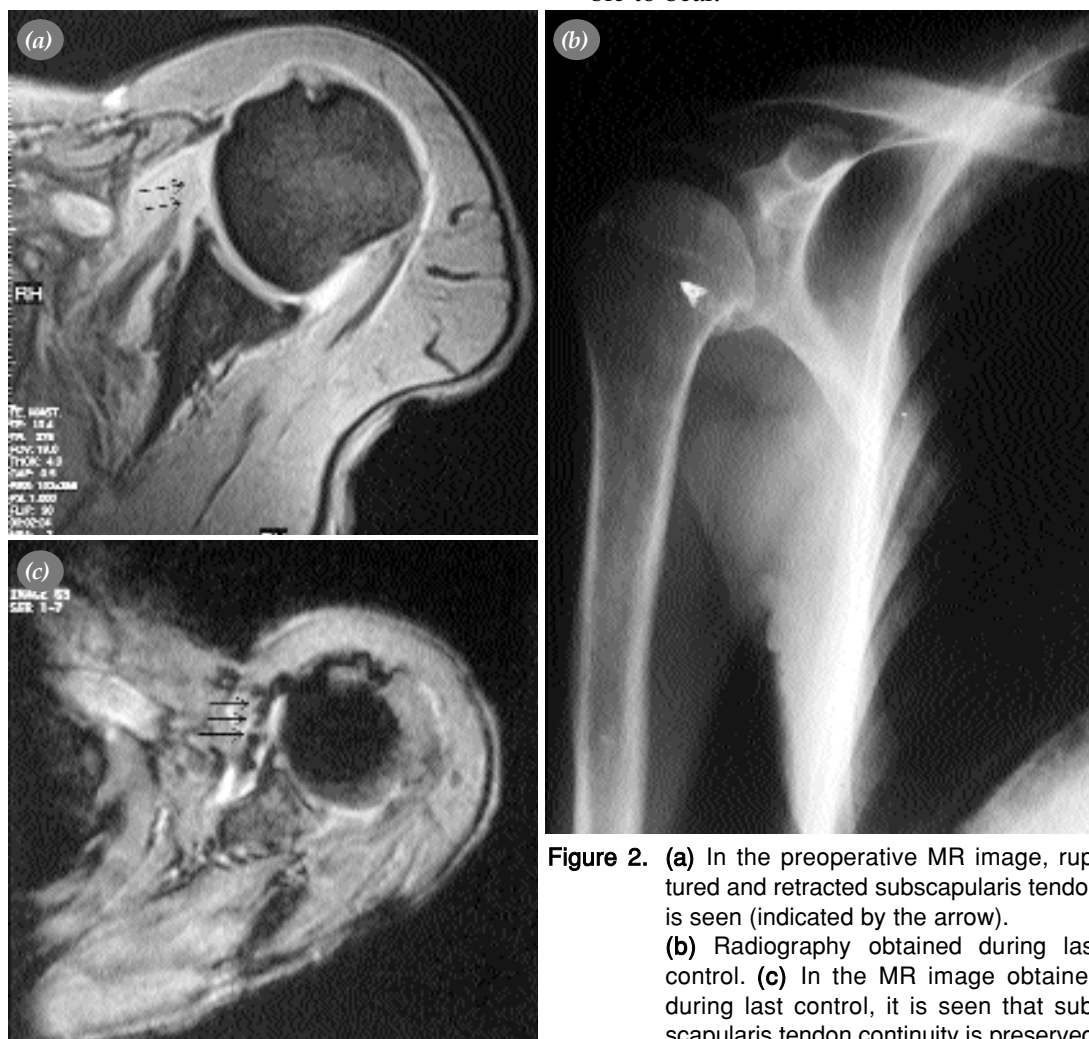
(a) In the preoperative MR image, ruptured and retracted subscapularis tendon is seen (indicated by the arrow). (b) Radiography obtained during last control. (c) In the MR image obtained during last control, it is seen that subscapularis tendon continuity is preserved.
